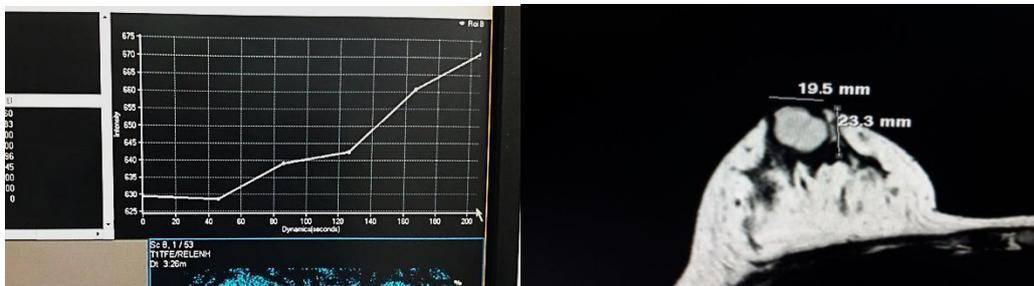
(DCE-MRI " type1 kinetic curve").
